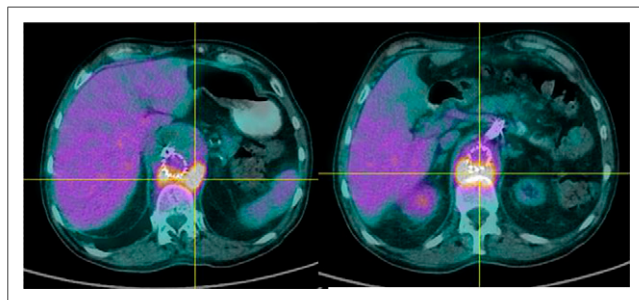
PET/CT images of male patient with aortic graft prosthetic material infection.
